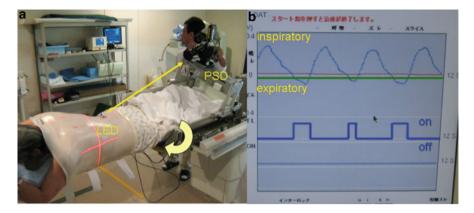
(a) Positioning for planning CT-scan. The patient is fixed onto the couch in prone position. The couch is rotated by 20° . A light emitting diode (LED) is attached to the patient's back and the light spot of the LED is focused onto a position-sensitive detector (PSD). (b) Respiratory waveform. The *green line* is the threshold of the lung excursion. The *blue line* is the on–off signal of the beam
